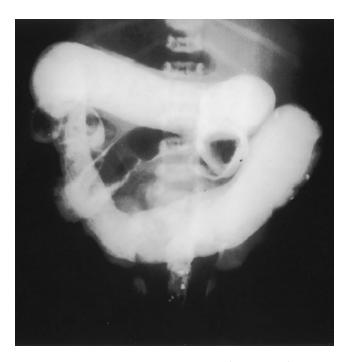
Barium enema radiograph from an infant with Hirschprung's disease. The dilated proximal bowel is the segment of bowel with normal ganglion cells. Note the narrow rectum and wide sigmoid. (*Courtesy of Dr. R. S. McCauley.*)
